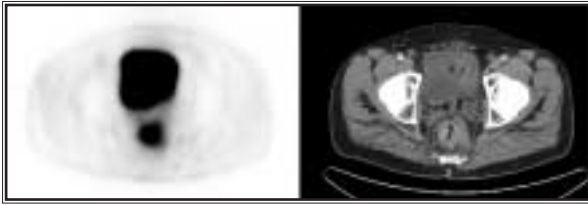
Primary rectal cancer in a 69-year-old man. Left: PET. Right: CT. Note hot bladder filled with excreted FDG.
